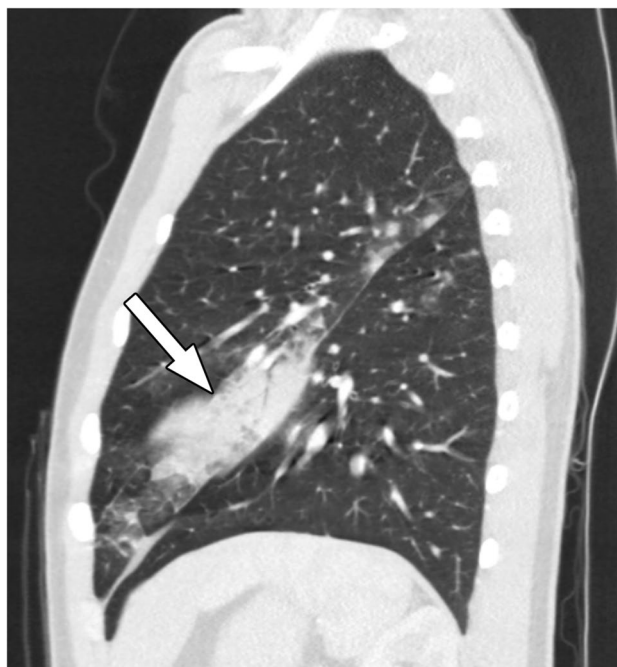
17-year-old boy with acute fungal infection due to histoplasmosis. Sagittal reformatted chest CT image with IV contrast material shows left upper lobe consolidation (arrow) with air bronchograms, mimicking bacterial community-acquired pneumonia
